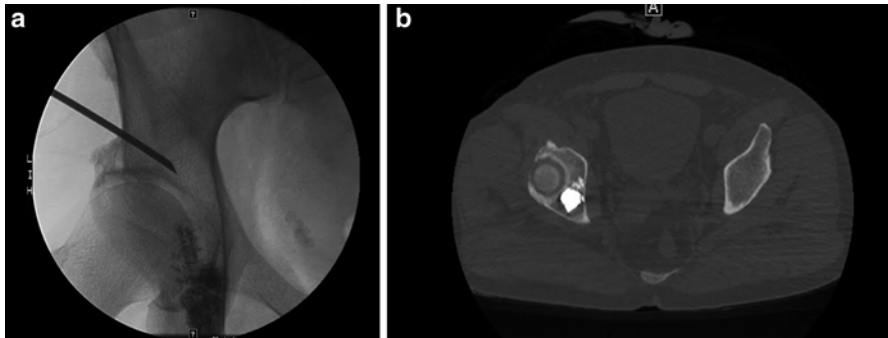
Interventional radiology images during cementoplasty procedure in the right ischium lesion. (a) Fluoroscopy image showing cement injection in the right ischium lesion. (b) Axial CT image showing cement in the right ischium lesion
